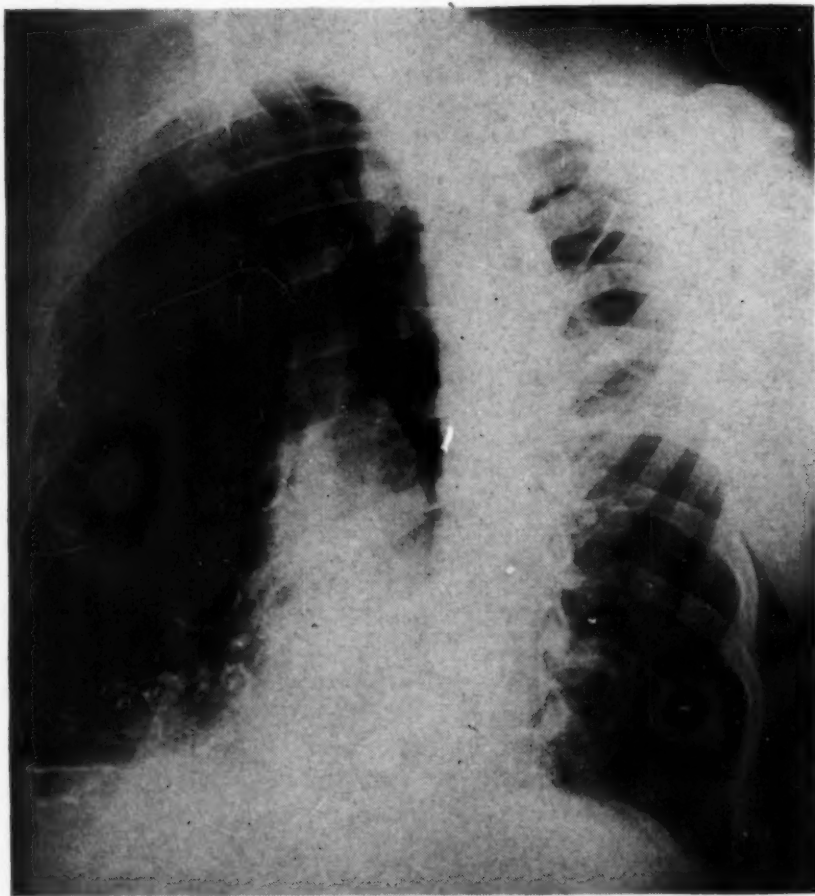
X-ray of chest in oblique position following injection of iodized oil into the pleural space, showing findings similar to Fig. 3.
